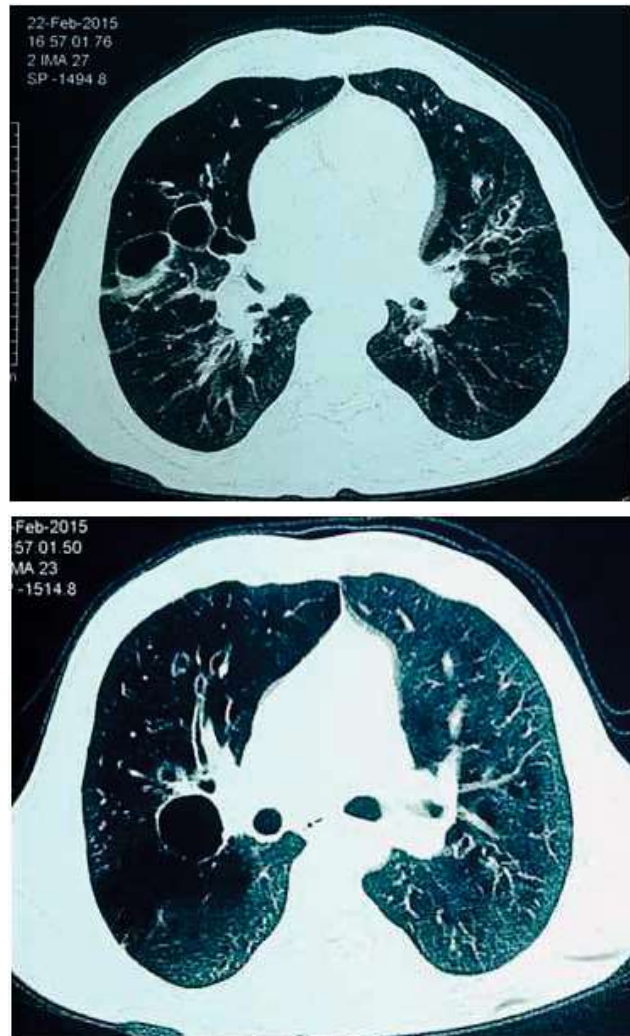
High Resolution Computed Tomography scan of chest demonstrated non homogenous opacity over right lower lobe with central bronchiectatic changes.
